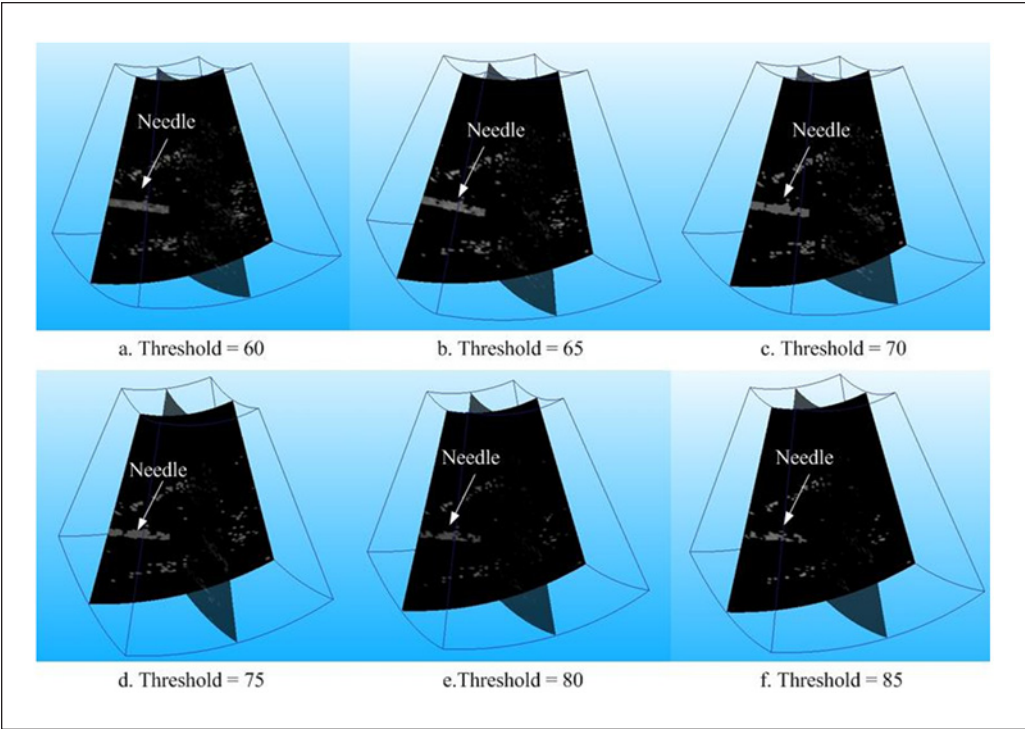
Different appearances of a needle in the 3D US volumes after the different thresholds, CR = 2.5. Note. 3D US = three-dimensional ultrasound; CR = contrast ratio.
